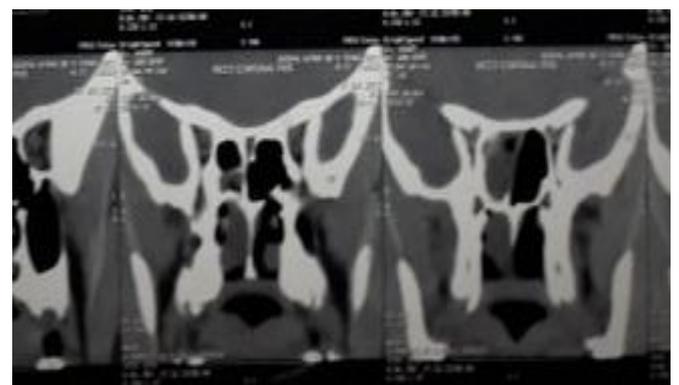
CT scan showing isolated sphenchoanal polyp.
